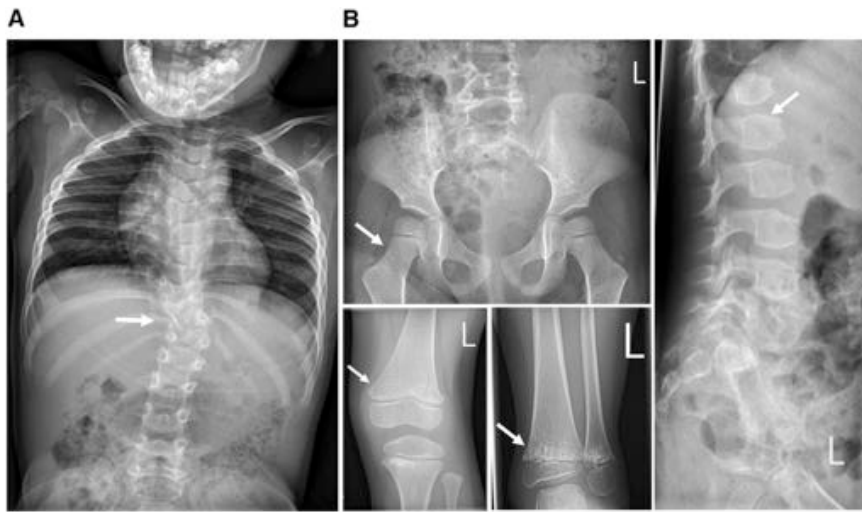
Radiographs Showing the "Corner Fractures" and Other Radiological Changes
